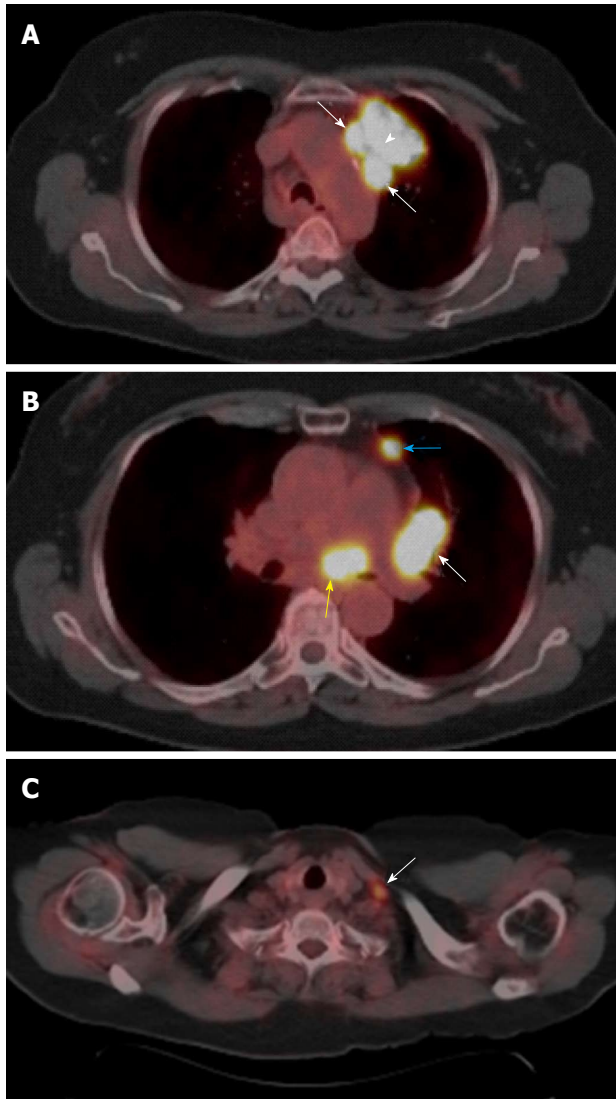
N descriptors. A: Primary tumor and N2: FDG-avid left upper lobe lung mass (arrowhead) invading the prevascular region of the mediastinum with adjacent FDG-avid level 6 lymph nodes suggesting nodal metastases (arrows); B: N1 and N2: Level 10L (white arrow), and 3A (blue arrow) enlarged lymph nodes with increased FDG avidity (N1 nodal metastases) and similar level 7 (yellow arrow) lymph nodes suggesting N2 nodal metastases; C: N3: FDG-avid left supraclavicular lymph node (arrow) suggesting N3 nodal metastases.
